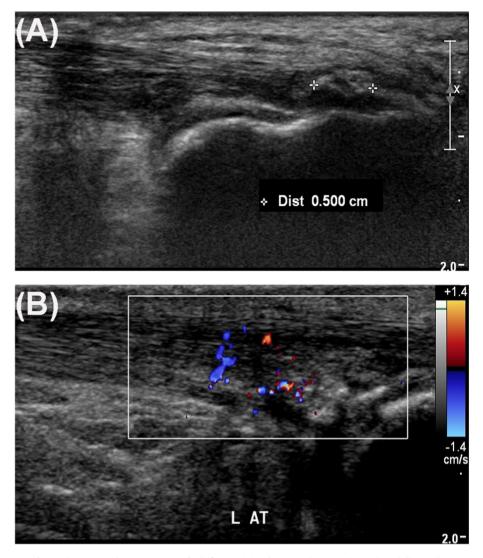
Ultrasonographic examination of calcification (A) and neovascularization (B) in the Achilles tendon.
